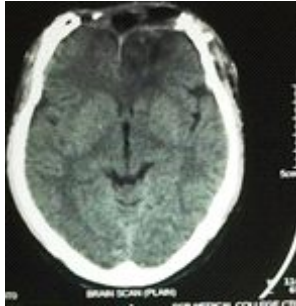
Post – op CT scan showing bifrontal decompressive craniectomy with contusectomy and lax duraplasty
